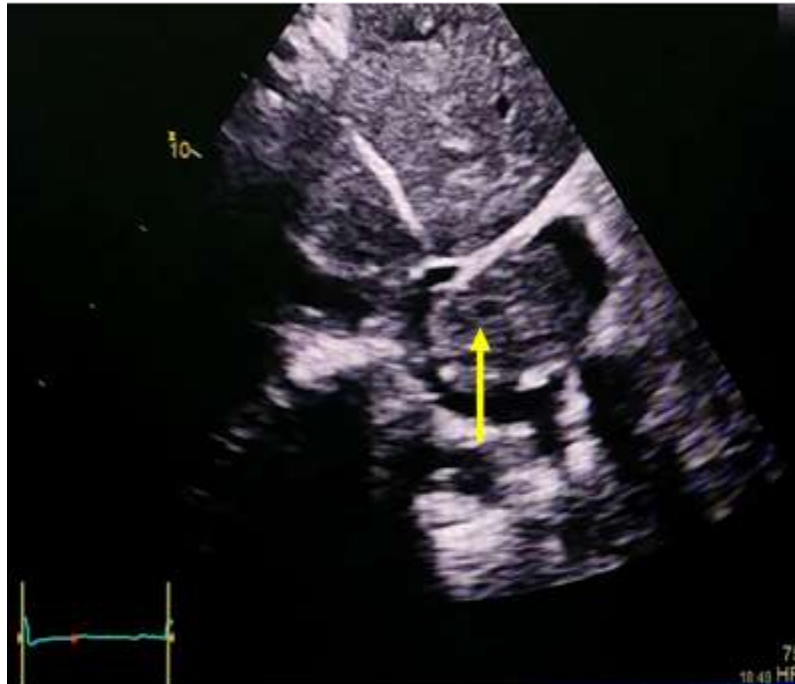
Two-dimensional transthoracic echocardiography (subcostal view) showed an echodense mass in the right atrium (arrow).
